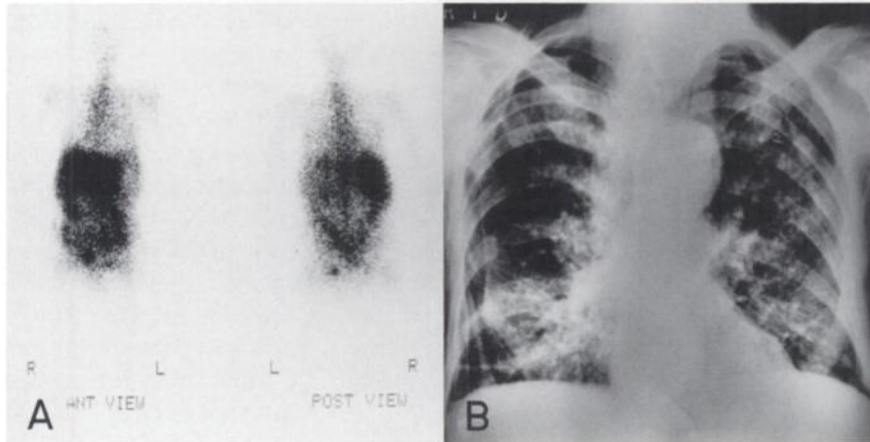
A 61-yr-old male patient. (A) The ^{67}Ga whole-body scan revealed no definite abnormality, including both lungs, but the chest x-ray demonstrated lesions in a miliary pattern (B).
